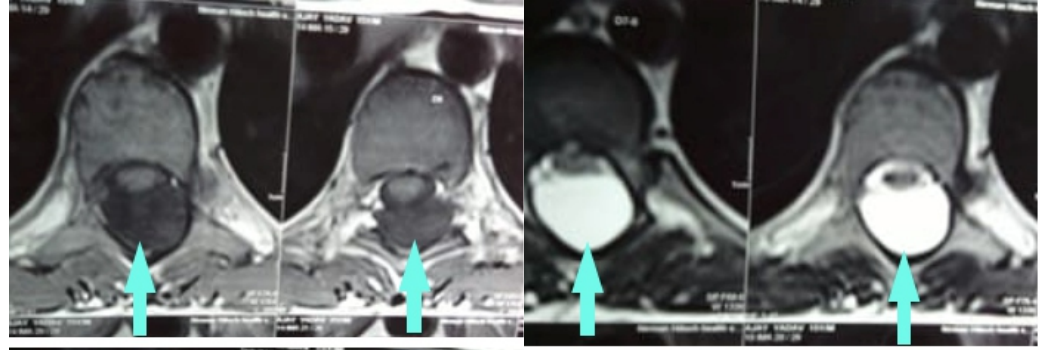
Axial cuts on MRI: T1W and T2W showing arachnoid cysts (Arrows shows compression in spinal cord)
